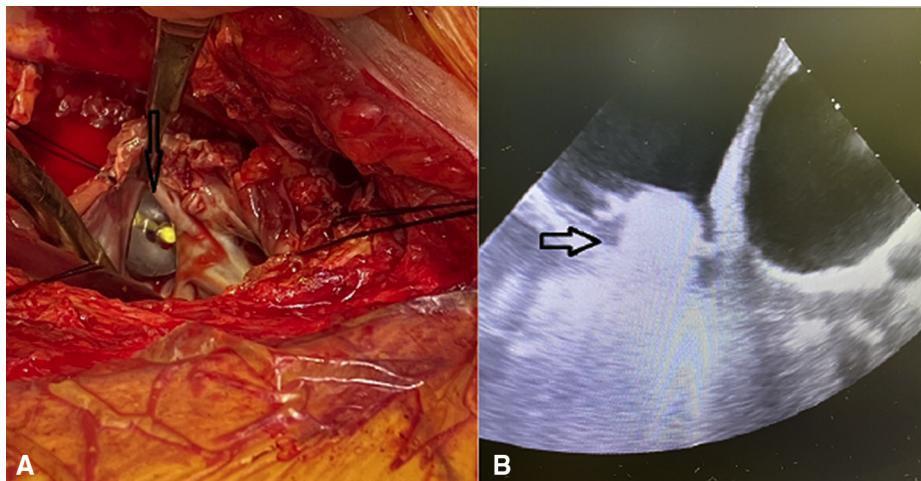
Intraoperative photograph (A) and transesophageal echocardiographic image (B) of the inflated Fogarty balloon catheter (arrows) occluding the SVC at the SVC–right atrial junction. SVC, Superior vena cava.
